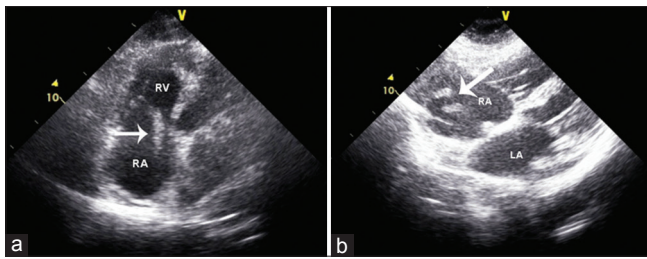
Apical four-chamber (a) and subcostal (b) views demonstrating highly erratic thrombus (white arrow) freely floating in the right atrium and protruding into the right ventricle. RA: Right atrium, RV: Right ventricle, LA: Left ventricle
